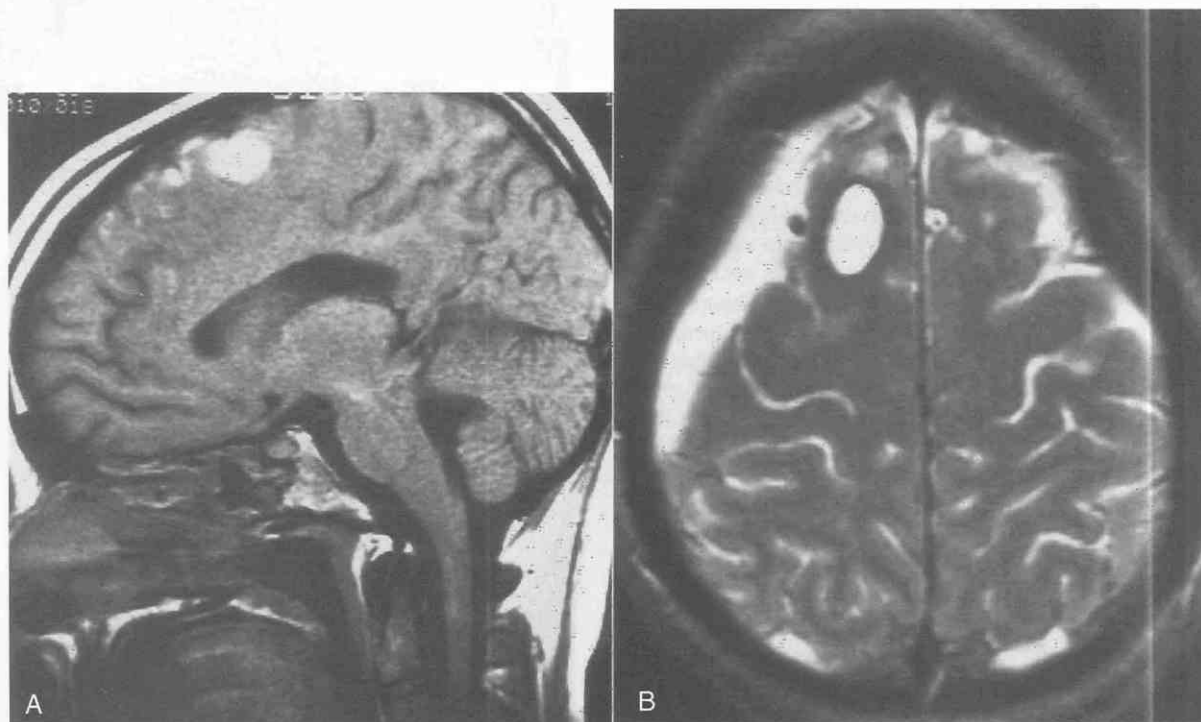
A and B, Right frontal lobe subacute intracerebral hematoma is hyperintense on sagittal T1-weighted (500/15) and axial T2-weighted (2500/80) MR images. The hyperintensity reflects the presence of dilute intracellular methemoglobin. Note the right convexity subacute subdural hematoma.
